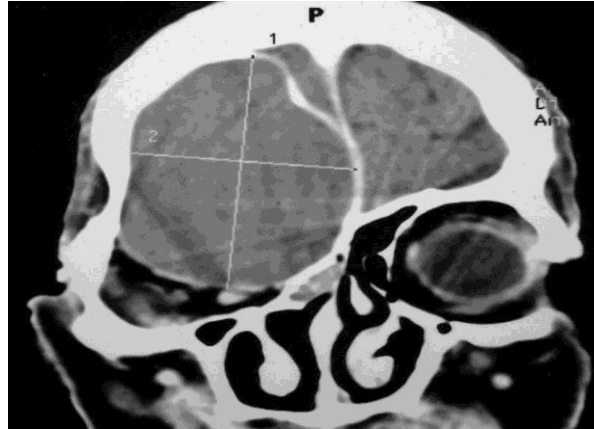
shows coronal soft tissue CT image with rt frontal sinus mucocele (<https://radiopaedia.org>)
